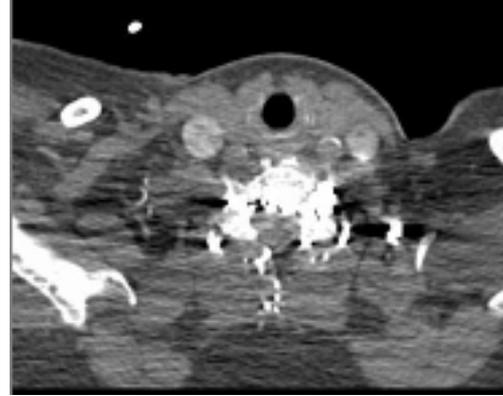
CT angiographic image of the dissection including the carotid artery
